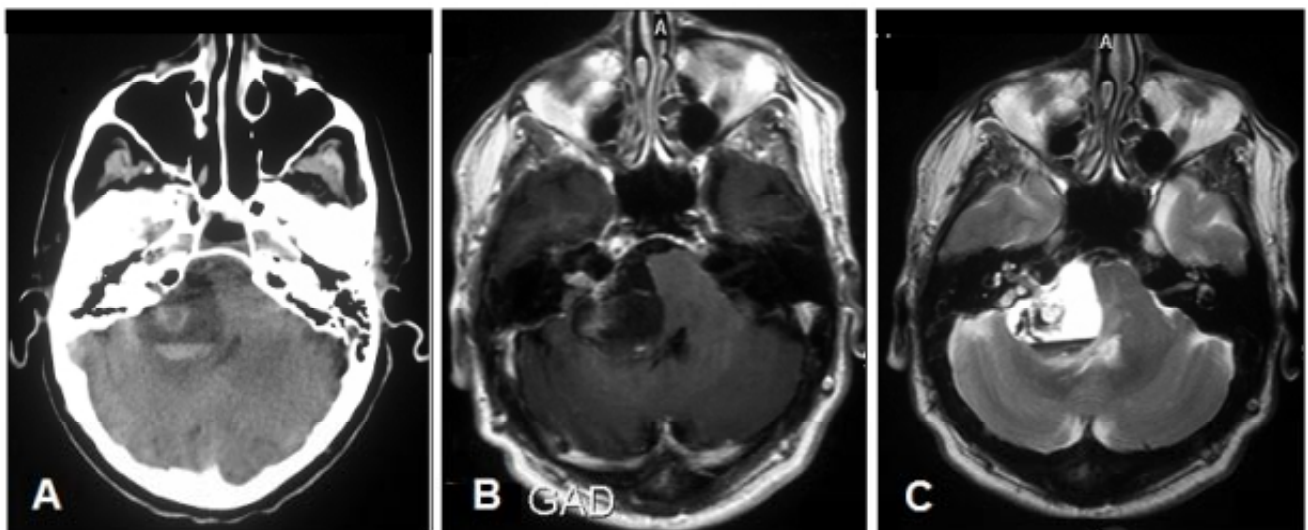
A: CT scan showing a low density lesion in the right CPA with a hyperdense intracystic component and fluid level. B: T1-weighted MRI scan with gadolinium enhancement showing some enhancement within the internal acoustic meatus. C: T2-weighted MRI scan demonstrating high signal in some areas of the cyst.
